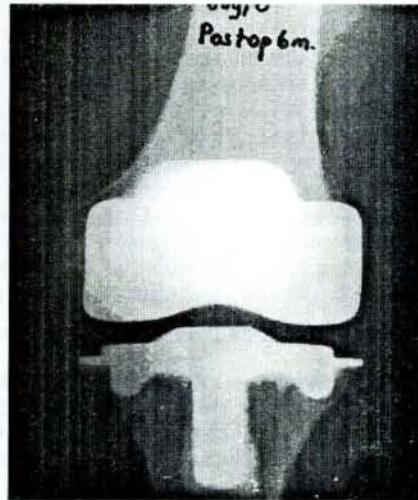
a: Postoperative 6th month PA X-ray
